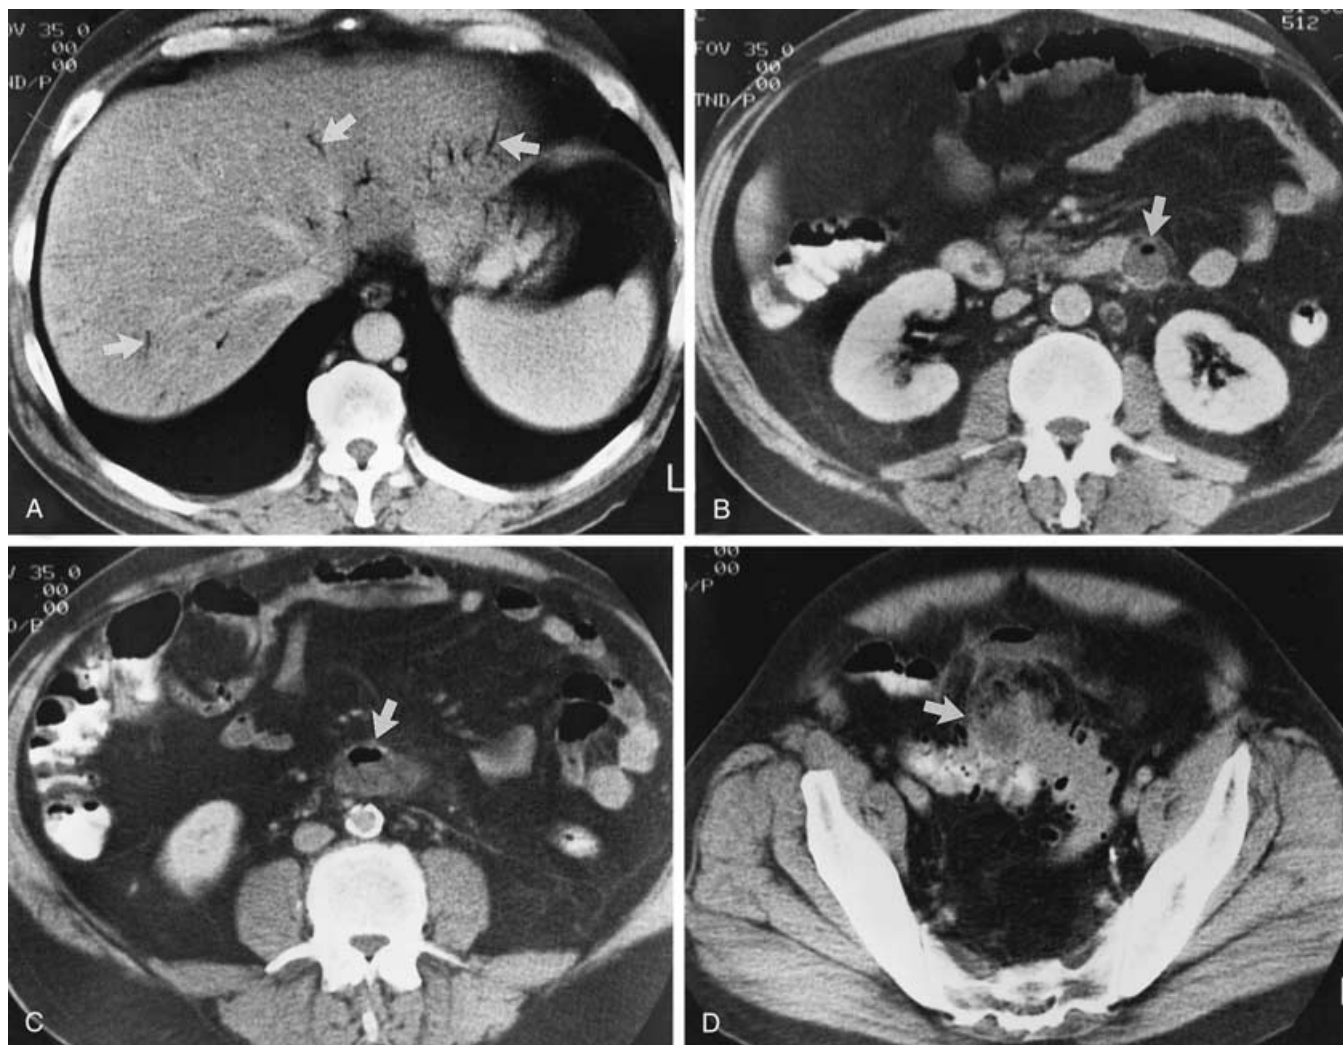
Acute pyelophlebitis resulting from diverticulitis with abscess. A, Minute quantities of gas (*arrows*) within peripheral branches of the portal venous system were not visible on a plain radiograph. B, A gas-containing thrombus (*arrow*) is visible in the inferior mesenteric vein at its junction with the splenic vein. C, A chain of abscesses (*arrow*) extended along the course of the thrombosed inferior mesenteric vein. D, The septic thrombus led directly to a pericolic abscess (*arrow*) caused by diverticulitis of the sigmoid colon.
